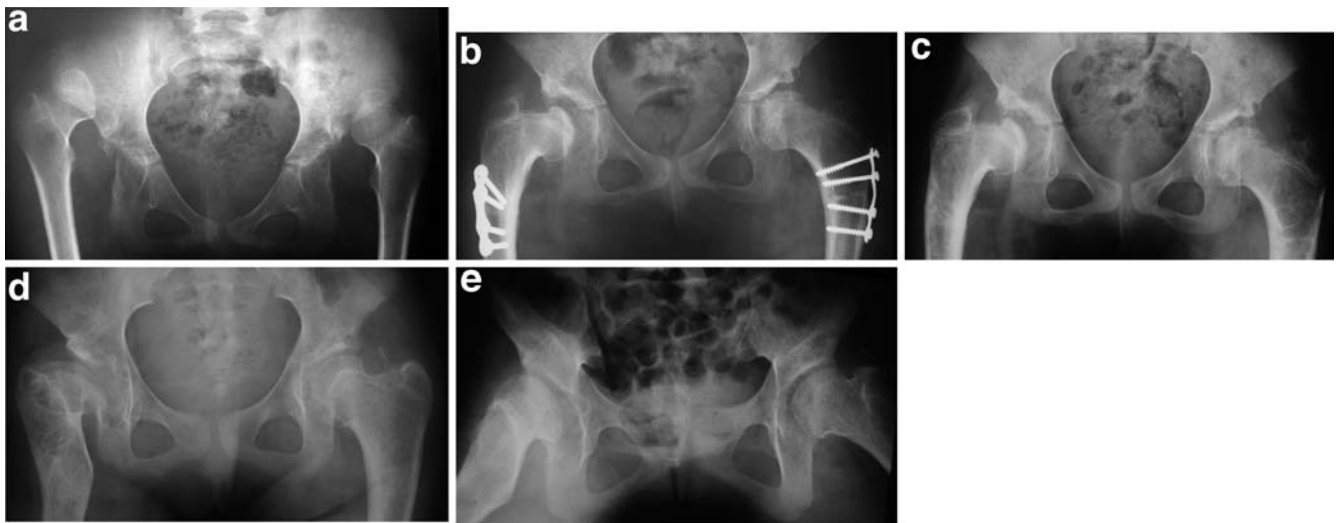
a Bilateral dislocation of the hip in an anteroposterior radiograph. b On the right side, there are signs of avascular necrosis of the femoral head 1 year postoperatively; the left is slightly affected (2 years postoperatively). c Four years
